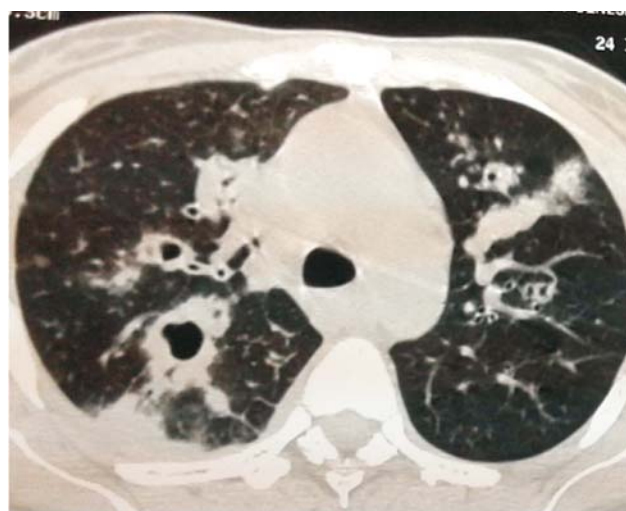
Computed tomograph of thorax of the same patient showing thick-walled cavitating nodules.
